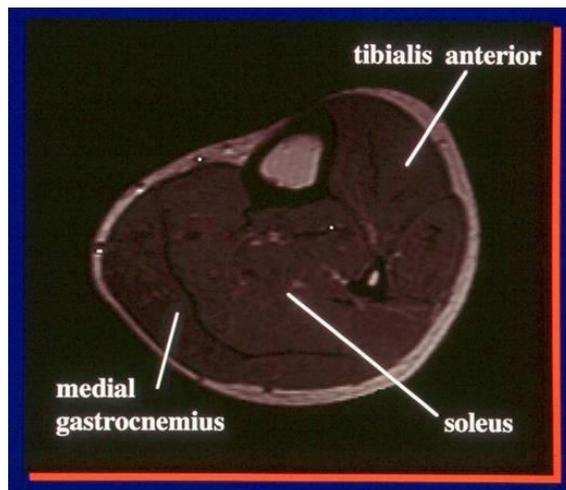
An MRI of the calf. The bright white components of an MRI represent tissue that contain dense concentrations of protons, such as water (blood) and fat.
